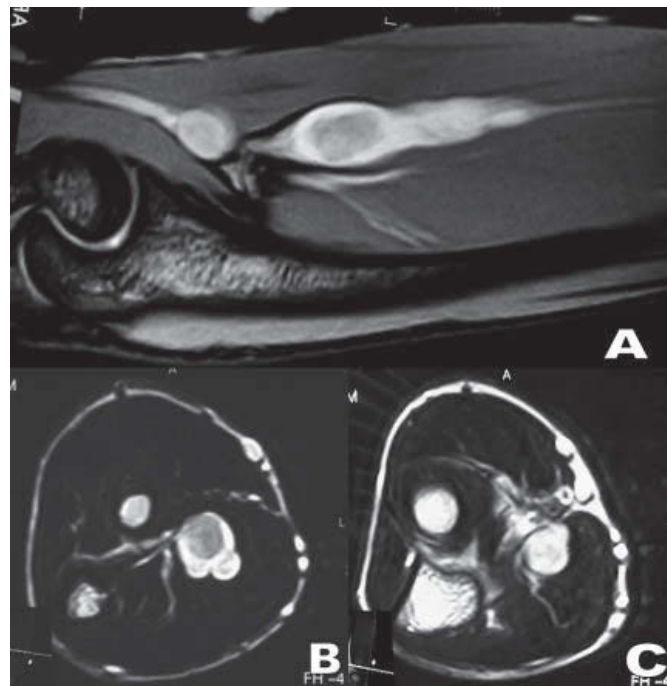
T2-weighted magnetic resonance scans. A: coronal view showing a spindle-shaped schwannoma encompassing the median nerve at the middle third of the forearm and a nodular schwannoma in the elbow. B: sagittal view showing a schwannoma developing eccentrically to the median nerve in the middle third. C: A schwannoma in the elbow.
